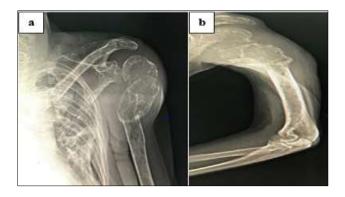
(a) Antero-posterior and (b) lateral view of left shoulder x-ray.
